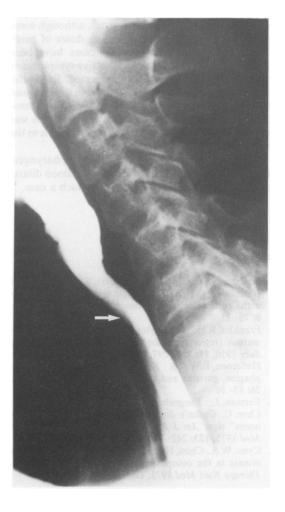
Radiograph from barium swallow showing a stricture of the oesophagus at the level of C6 (arrowed).
